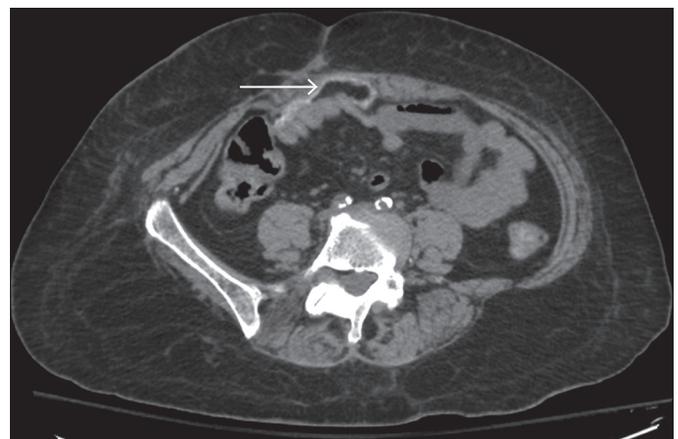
Computed tomography angiography of the abdomen and pelvis showing a ventral mesh without evidence of bleeding and perforation.
